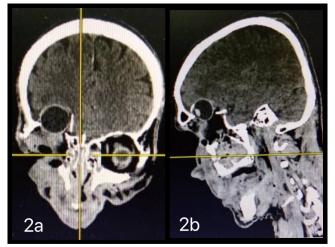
(a) Coronal view of computed tomography scan of the brain and orbit noted displaced right eye globe into the right anterior cranial fossa with orbital wall fractures. (b) Sagittal view of computed tomography scan of the brain and orbit noted displaced right eye globe.
